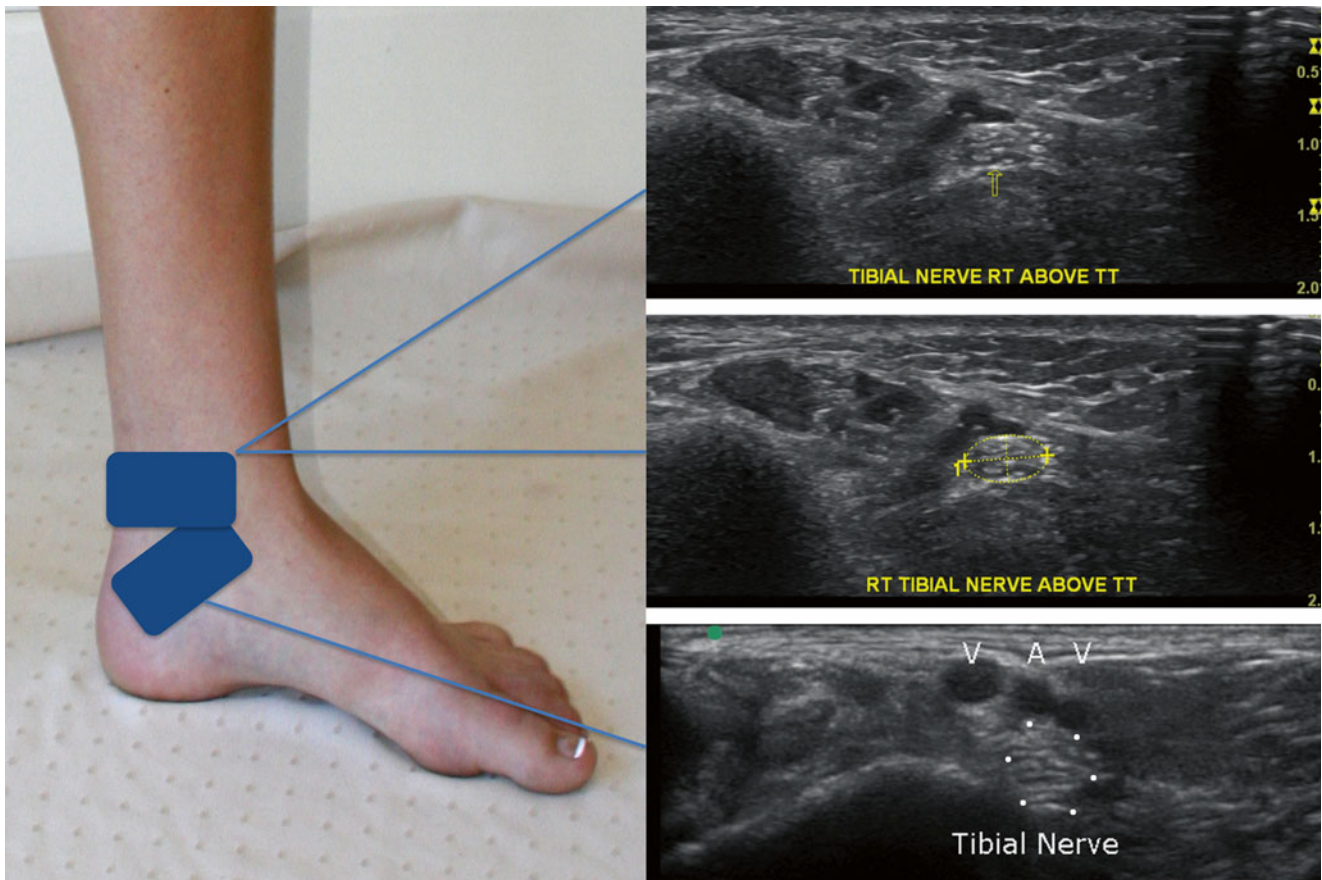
Ultrasound evaluation of the tarsal tunnel (Image courtesy of Michael Brown, MD)
